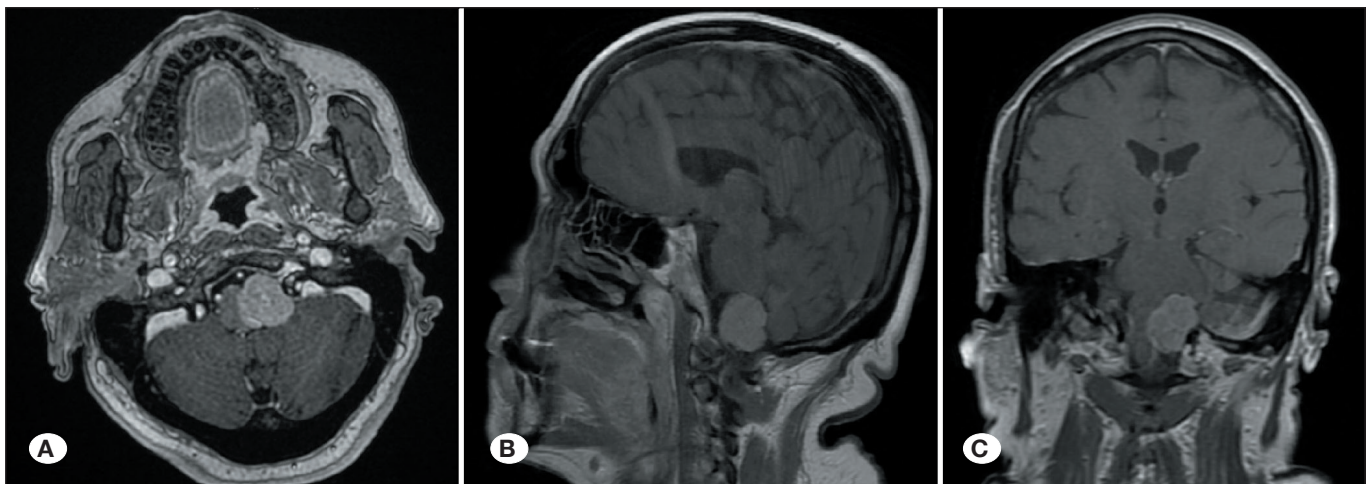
Preoperative contrast enhanced T1W magnetic resonance imaging scans revealed a well-circumscribed, diffusely enhancing left-sided lesion at the level of the foramen magnum (A: axial, B: sagittal, C: coronal sections). The imaging characteristics were suggestive of a meningioma; however, the absence of a clear dural attachment raised the differential diagnosis of other pathologies, including a schwannoma or, less commonly, a meningioma not originating from the dura.
